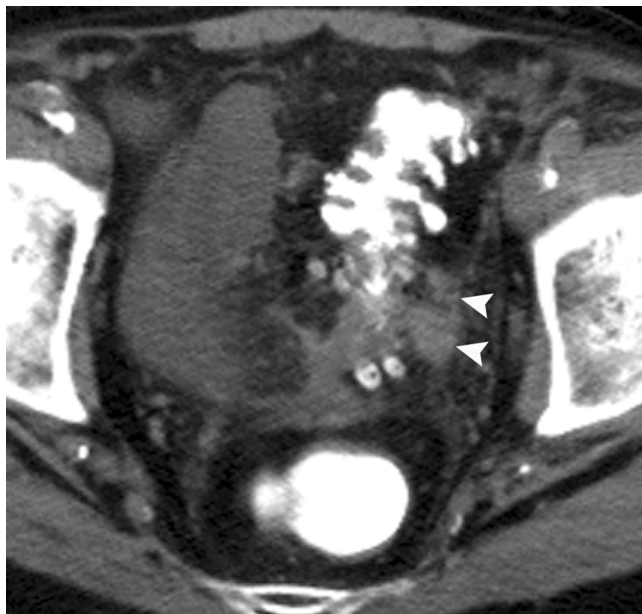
Axial contrast-enhanced CT through the pelvis of a patient with advanced gastric cancer. Nodular deposits are seen on a thickened peritoneal surface (white arrowheads), suspicious of peritoneal metastases. Peritonitis carcinomatosa caused by the stomach cancer was confirmed at laparoscopy.
